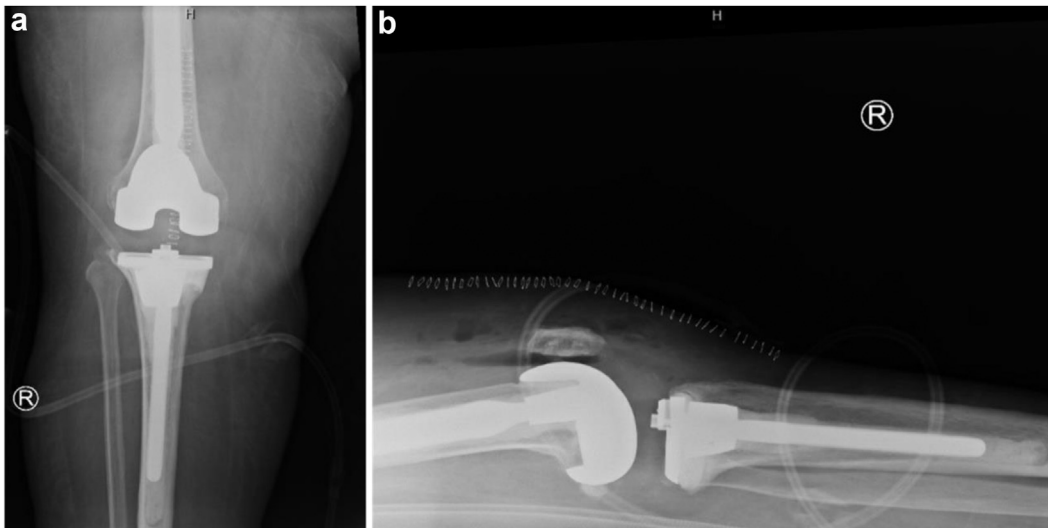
Postoperative anteroposterior (a) and lateral (b) radiographs.
